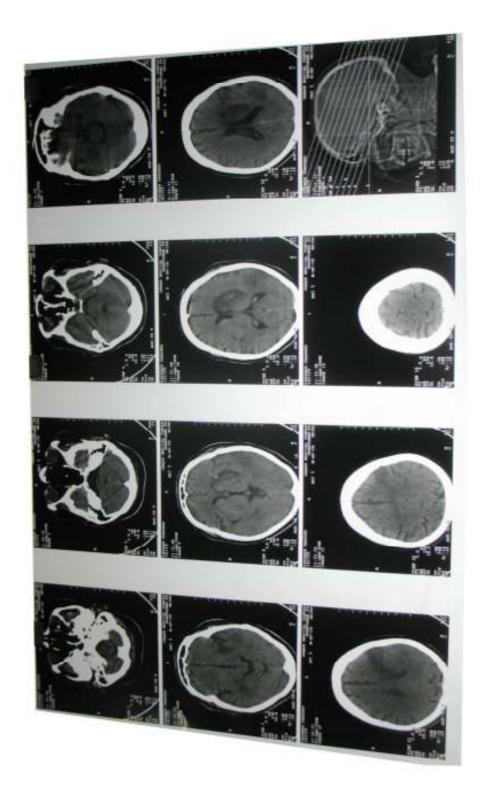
Figure f: CT scan of case f (M.M.). Lesion can be seen in the left striatocapsular area.
